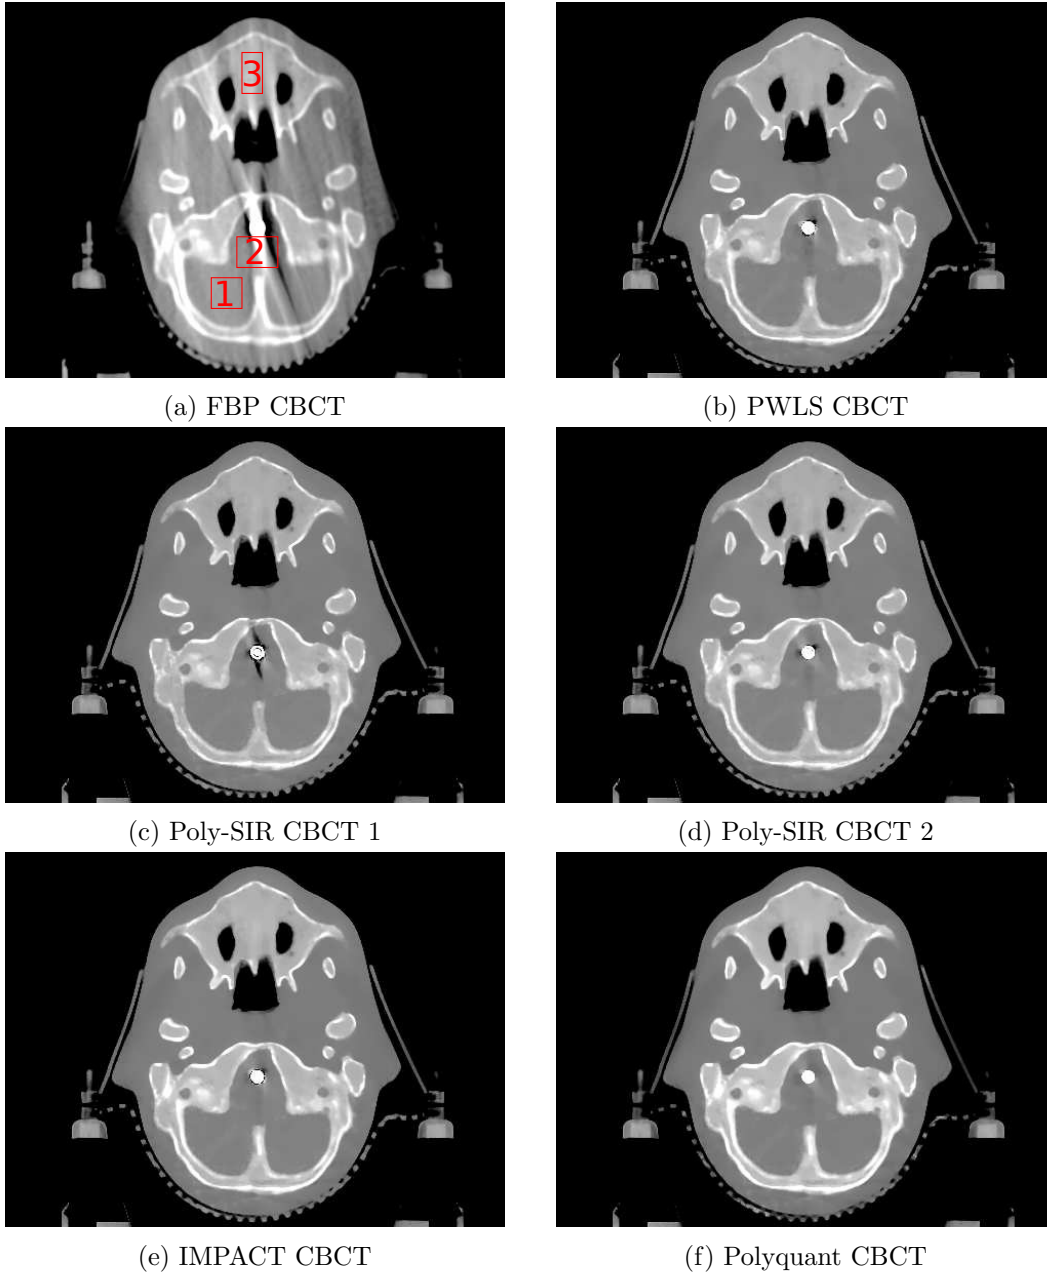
Results from electron density reconstruction from real CBCT data showing slice 83, where each is shown with display window  $[0.7, 1.4]$ : (c) is Poly-SIR given a bone and metal segmentation derived from the FBP; (d) uses a segmentation derived from the PWLS.
